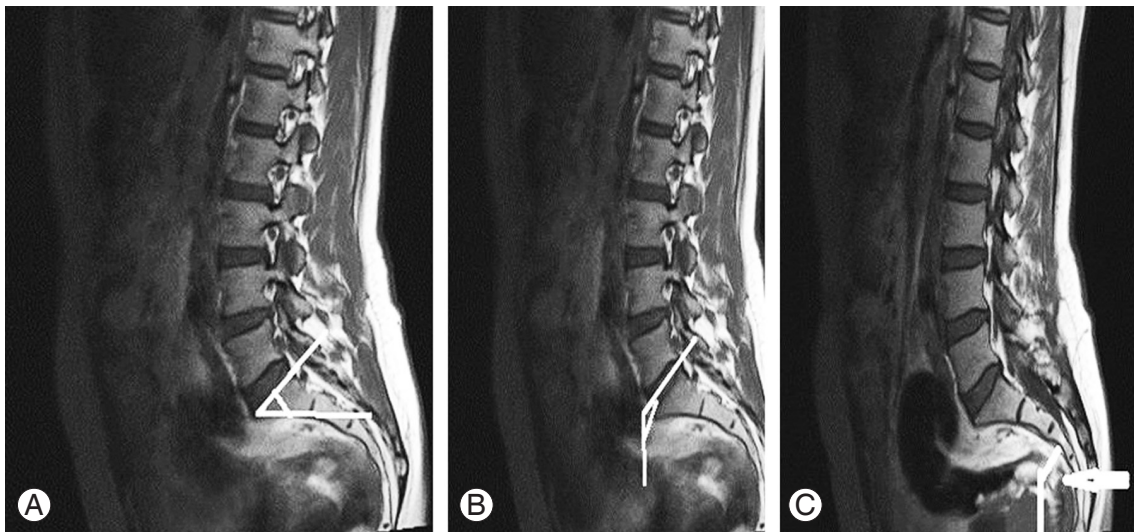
Magnetic resonance imaging angles used in this study. (A) Sacral slope. (B) Vertical angle of sacrum. (C) Central sagittal angle of the sacrum.
